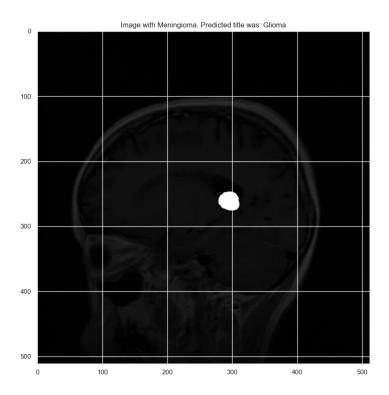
MRI of Meningioma as which MLP model predicted Glioma
